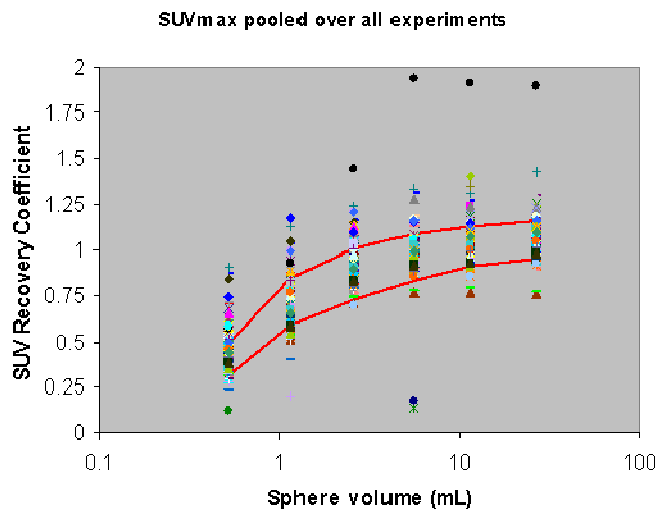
Results of SUV Recovery Coefficients (RCs) from 55 PET/CT systems before EARL FDG-PET/CT accreditation: A high SUVmax RCs variability between sites is shown (no vendors indicated). A clear contrast with the results in figure 2 can be seen, indicating the need for a harmonising PET/CT scanner accreditation programme as performed by EARL.
